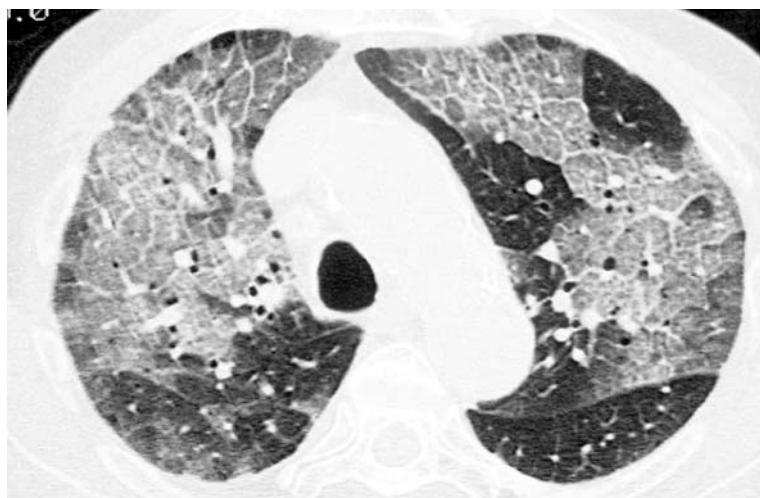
A 53-year-old woman with SLE and diffuse pulmonary hemorrhage. HRCT scan shows extensive bilateral ground-glass opacities with superimposed thickening of the interlobular septa with a 'crazy-paving' appearance.
